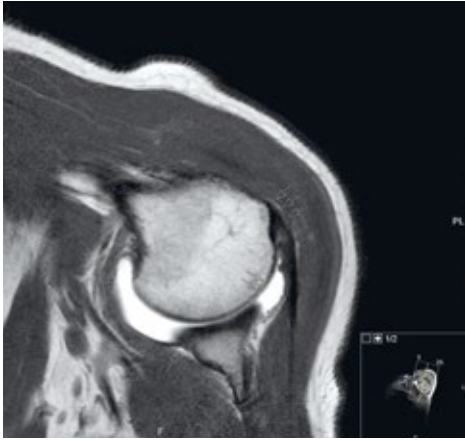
Example of three normal structures (ABER position orientation, T1-weighted): normal labral attachment on the anterior-inferior glenoid (single arrow), a normal humeral head contour (double arrow) and a part of the normal footprint attachment of the supraspinatus tendon (triple arrow)
